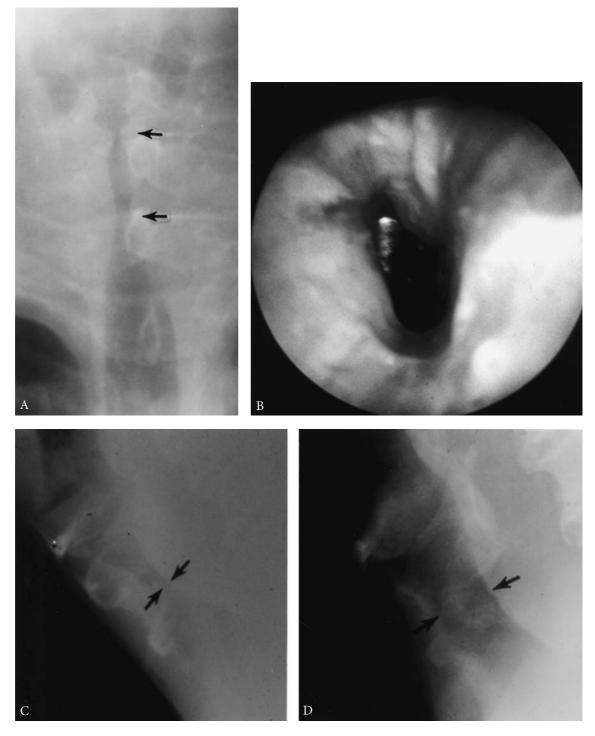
Subglottic postintubation stenoses. A, Roentgenogram of the larynx and upper trachea. A slight 25-year-old man was ventilated with an endotracheal tube for head injury. Upper arrow indicates the vocal cord level. Lower arrow is at the cricoid level, also the point of maximum stenosis. The entire subglottic space is markedly narrowed. B, Laryngoscopic view just below the glottis in the same patient. The stenosis is severe, irregular, but circumferential. The glint of a tracheostomy tube is seen distally. Tracheostomy was necessary prior to laryngotracheal resection and reconstruction. C, Laryngotracheal stenosis following ventilation via "high tracheostomy," probably cricothyroidostomy, after repair of ruptured chordae tendineae in a 71-year-old man. Lateral cervical roentgenogram. Arrows indicate severe constriction of the lower larynx and trachea. D, Airway restoration following laryngotracheal reconstruction. Normal lumen is restored (arrow). See also Figure 28 (Color Plate 15).
